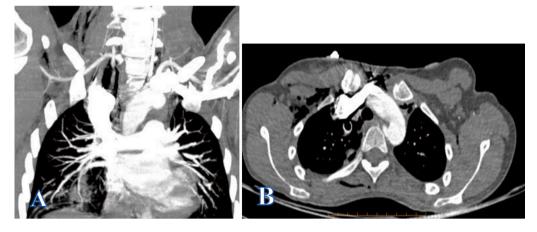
a and b Preoperative contrast-enhanced CT scan shows: a non-aneurysmal arteria lusoria stump after surgery.
